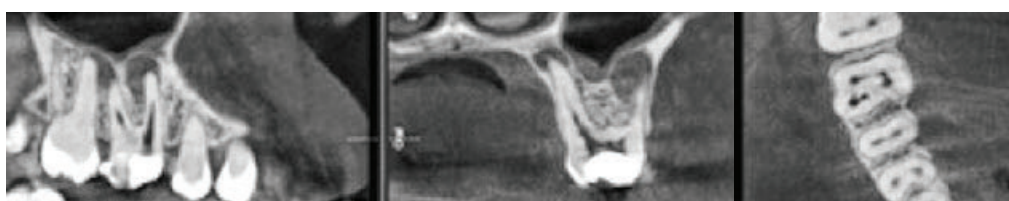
Images taken at coronal third level of roots. Orthophos SL axial image shows four major orifices, with two mesiobuccal canals. Periapical lesion is present with both buccal roots.
